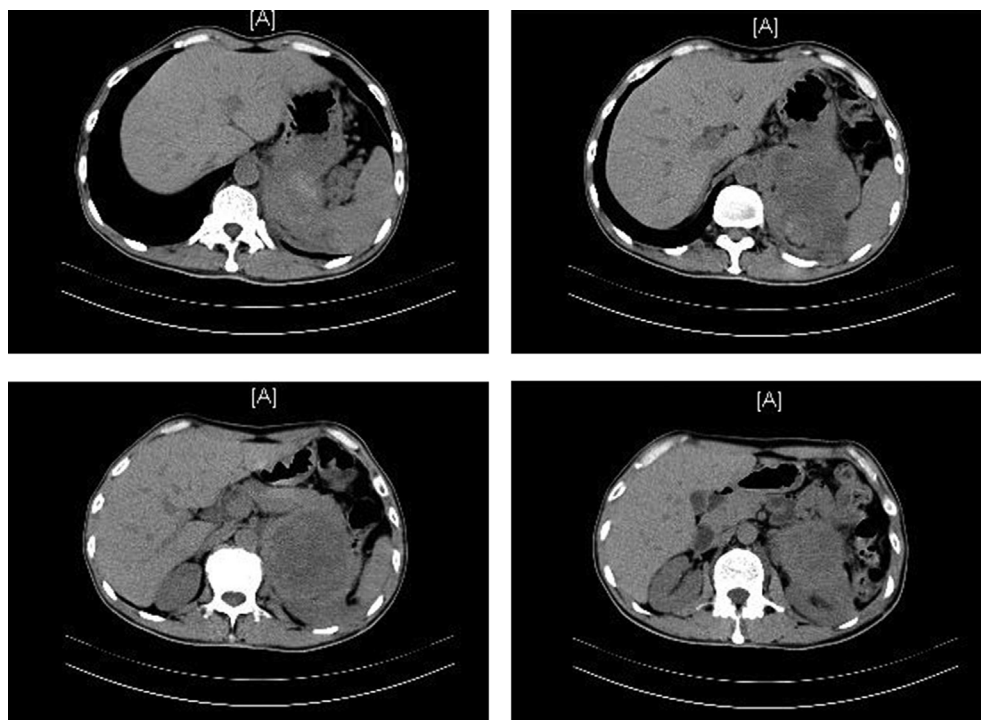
CT scan indicated masses on the left adrenal area in one month after surgery.
